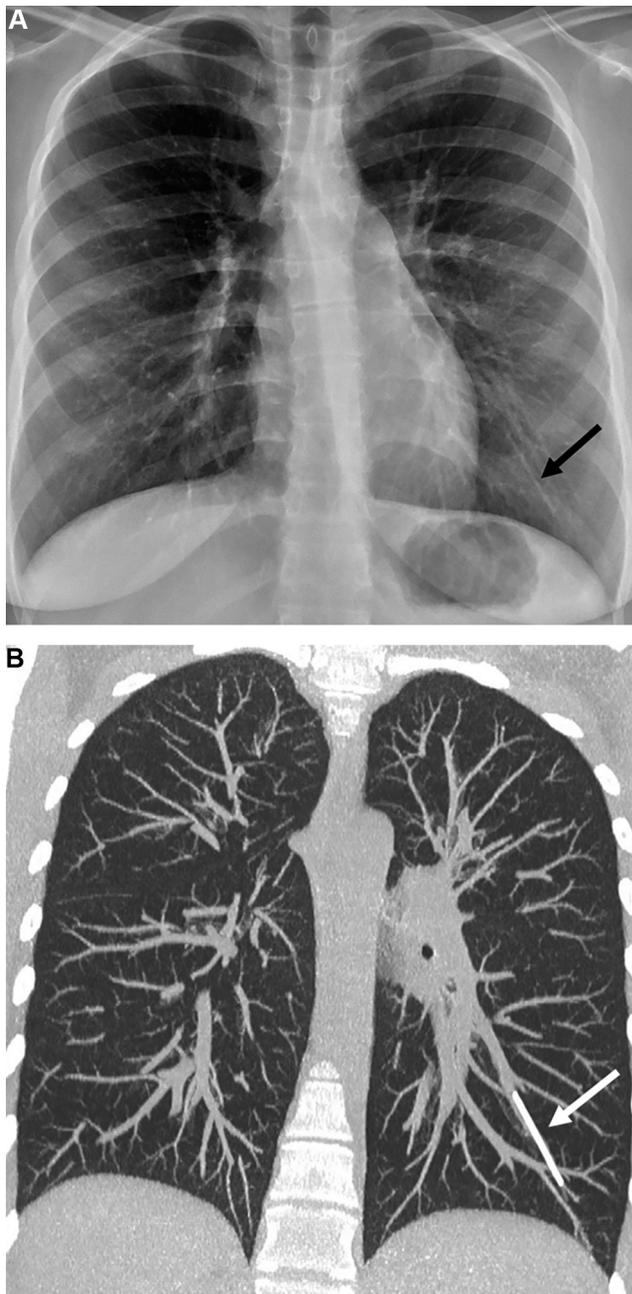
A. Chest X-ray demonstrates the implant (arrow) in the left lower lobe. B. Coronal CT image demonstrates the implant (arrow) in the latero-basal segmental pulmonary artery of the left lower lobe.
